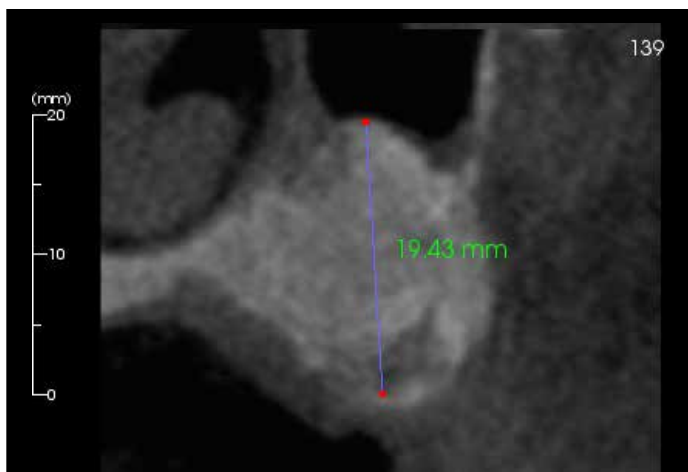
Postsurgical CBCT scan of the left maxillary sinus showing bone fill at 120 days.
